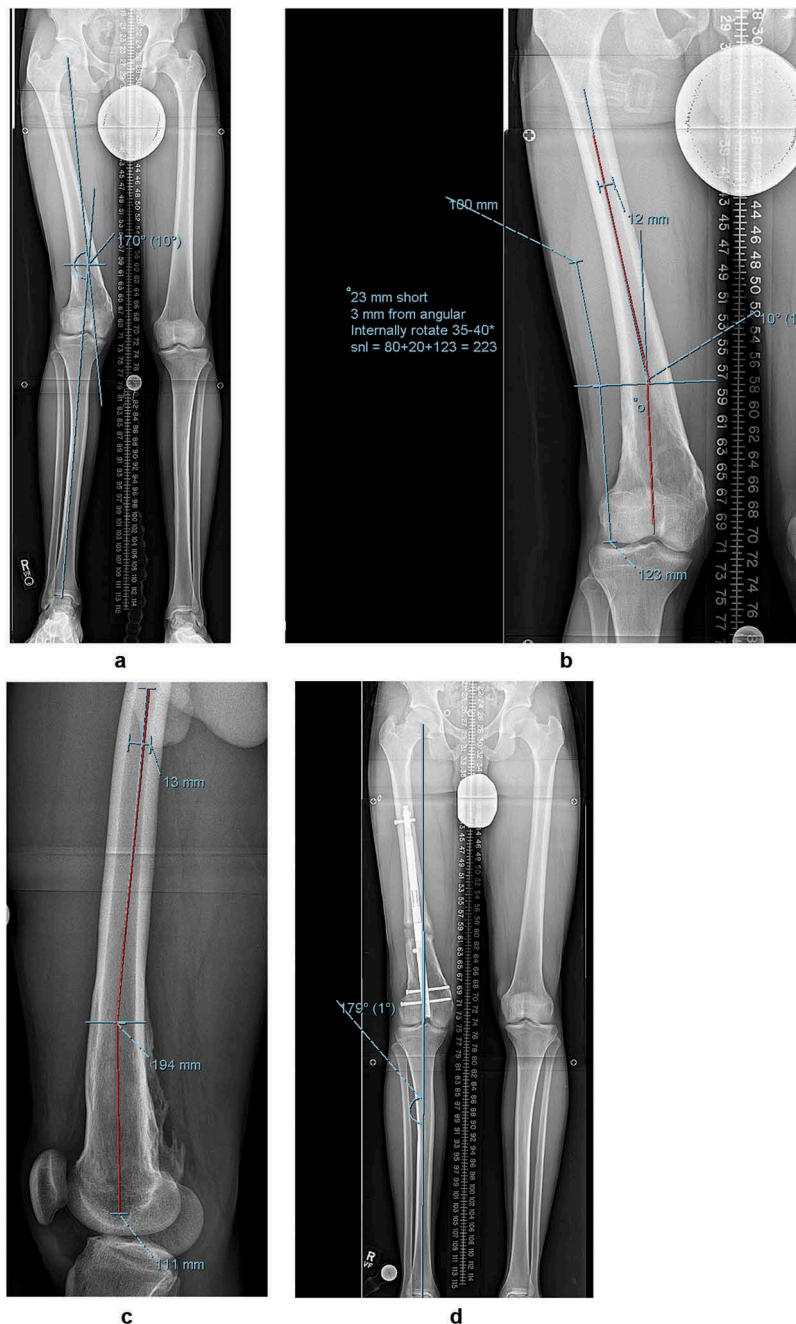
(a) This patient suffered from a post traumatic valgus deformity and LLD of 23mm. Indications for lengthening surgery included non-compliance with a shoe lift, asymmetric coronal alignment, and a safe method for limb length equalization. Mechanical axis planning of this valgus deformity, with the distal axis placed through the center of the knee, yields a quantity (10 degrees) and location for corrective osteotomy and lengthening of 23mm. (Alternatively, the distal axis could have been moved 2.3mm medially to compensate for the 2.3mm lateral shift during lengthening.) (b) Translation of the MA planning is done by placing the proximal portion of the nail in the diaphysis (proximal red line) and then aligning the distal portion at an angle of 10 degrees starting from the notch (distal red line). Notations are also made of the desired rotational correction and the shortest nail length calculation. The 100mm line extending from the osteotomy site proximally is the most important aspect and is comprised of accounting for the 50mm of thick portion of the nail needed in the proximal fragment at the completion of lengthening, the 30mm thinner telescoping section of nail, and the desired length (rounded to 20mm in this case). This length of 100mm is added to distal portion (123mm) to yield the shortest nail that will accomplish the lengthening accurately (223mm). (c) The lateral radiograph then dictates the longest nail length possible as the nail tip needs to lie distal to the bow. This shows that a 305mm nail is the longest possible for this patient. (d) This post lengthening radiograph shows a 1 degree valgus (3mm lateral MAD) residual deformity. Because the lateral MA shift was not addressed in the planning the patient remained in slight valgus. An 11 degree correction would have been predicted by moving the distal MA 2.3mm medially during planning.
